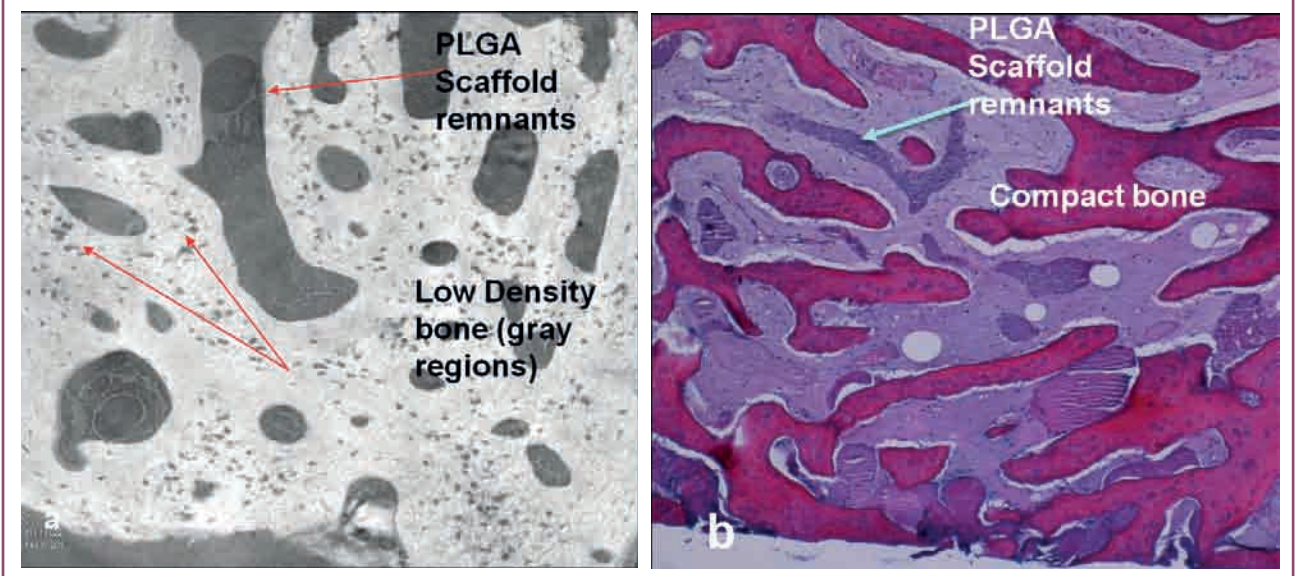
Micro CT 3D image of Bioscaffold regenerated bone sample @ 1 μm resolution
